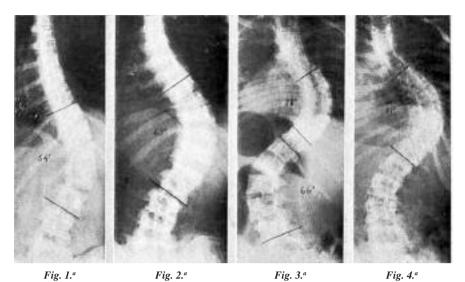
Spine radiograph of a 17-year-old girl showing lumbar curvature. The deformity became noticeable at age 12. Figure 2. X-ray of a 17-year-old girl with thoracolumbar curvature. The deformity became noticeable at age 11.
